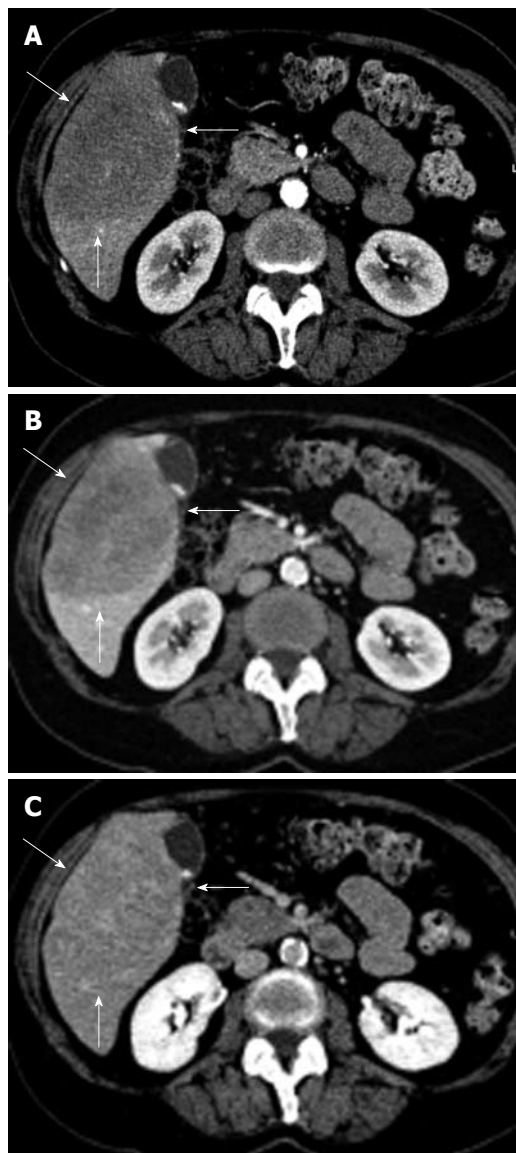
Radiological depiction of the liver lesion. Arterial (A), portal (B) and equilibrium phase (C) computed tomography scan with a large (10 cm × 8 cm × 7.5 cm) hypovascular lesion in segments V and VI of the liver with some inhomogeneity and without calcifications (lesion indicated by 3 white arrows).
